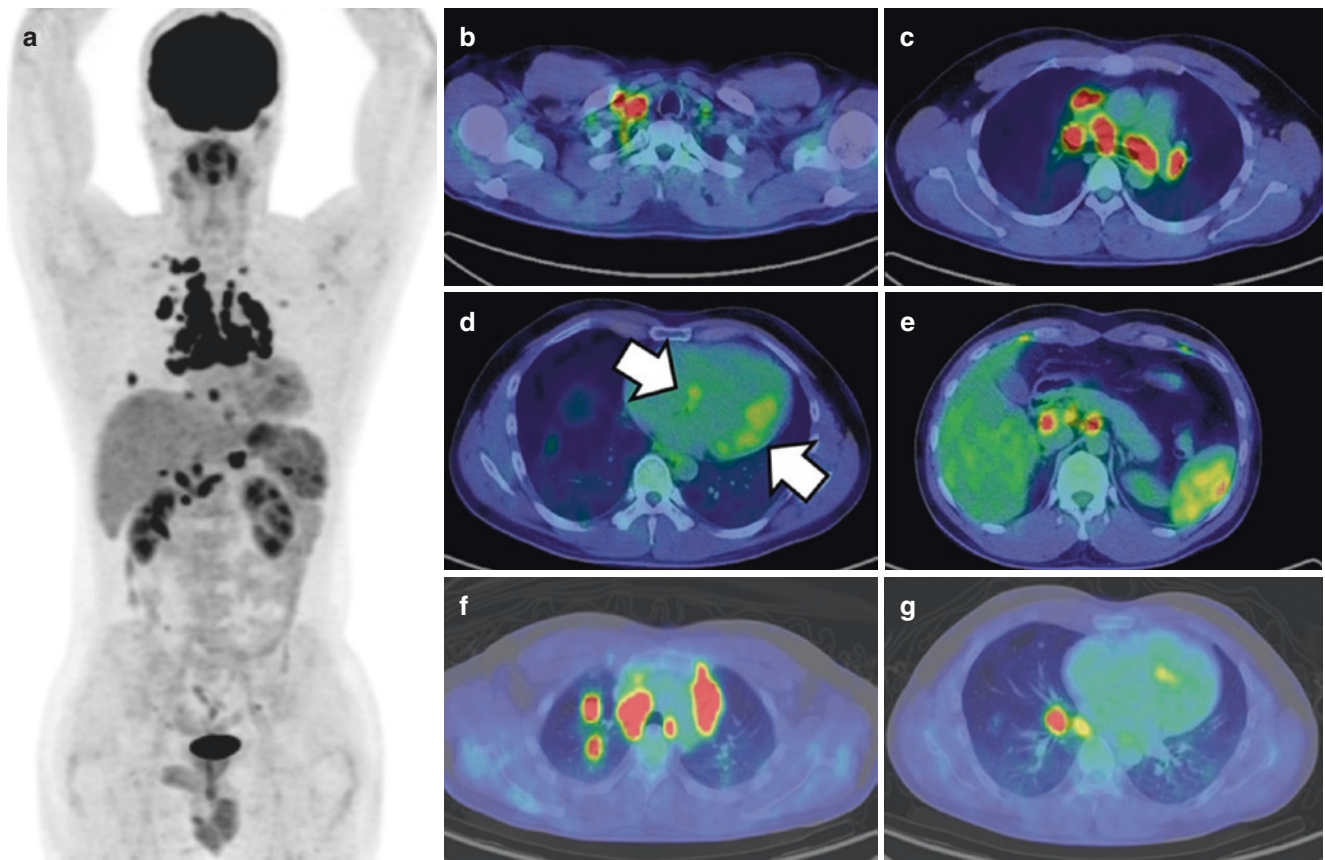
FDG PET/CT at the patient's initial visit
